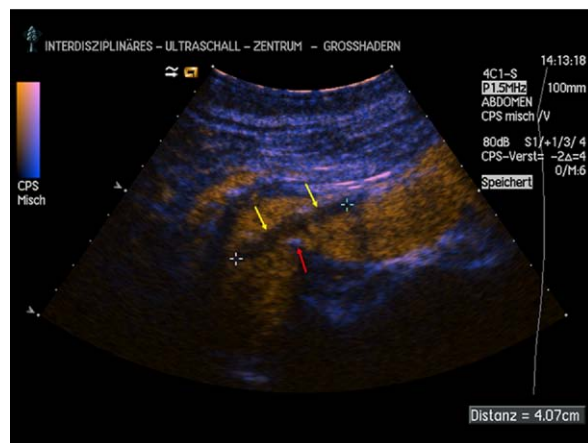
Visualization of the proximal infrarenal landing zone by intraoperative contrast-enhanced ultrasound (iCEUS) using an endoluminal balloon catheter dilatation (yellow arrows), giving a contrast-sparing zone within the aortic lumen. The length of the balloon catheter is measured between the white cross markers (measured length: 4.07 cm; original length of the catheter as described by the manufacturer: 4.0 cm). The red arrow shows again the kinking of the aorta. Stent graft release was planned within the straight infrarenal aortic segment just below the zone of aortic kinking.
